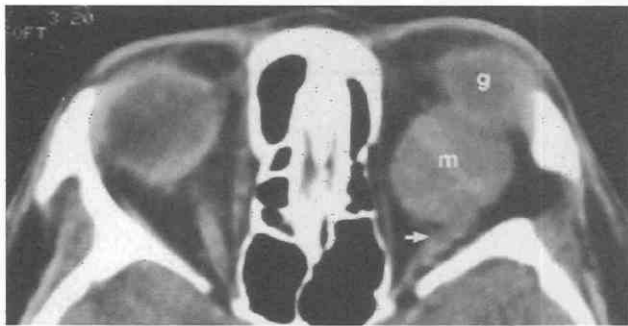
Axial contrast-enhanced CT scan shows optic nerve sheath meningioma. m, meningioma; g, globe; arrow, displaced optic nerve sheath complex emerging from mass.
